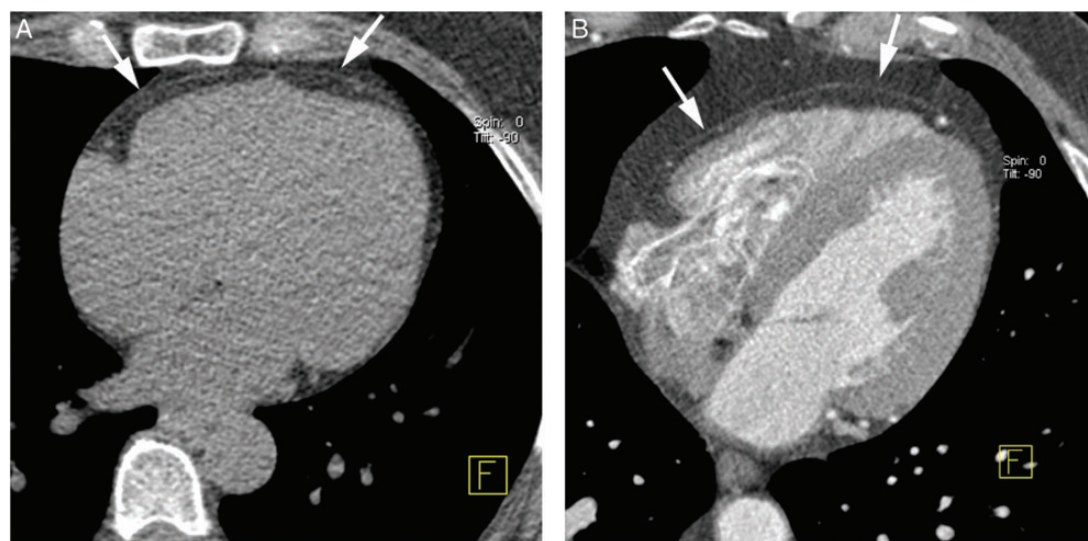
Visualization of the pericardium in computed tomography. Both in non-contrast acquisitions (A) as well as in contrast-enhanced acquisitions (B), the pericardium can be visualized as a thin line embedded in the epicardiac and paracardiac fat (arrows). Where the pericardium is immediately adjacent to the myocardium, it can often not be visualized. Frequently, this is the case along the posterior margin of the heart.
